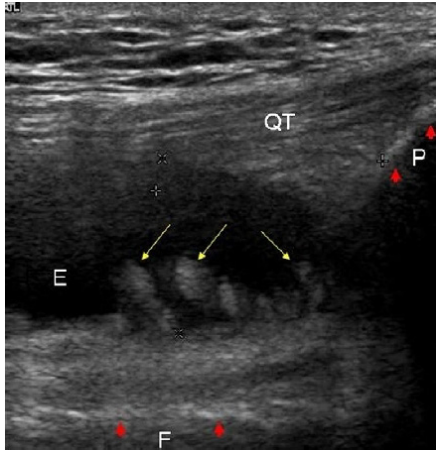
OA in the knee. A longitudinal ultrasound image through the suprapatellar pouch demonstrates synovial hypertrophy with villi formation (yellow arrows) and an effusion (E). The cortical surface of the femur (F) and patella (P) are indicated by the red arrows, and the quadriceps tendon (QT) is also shown.
